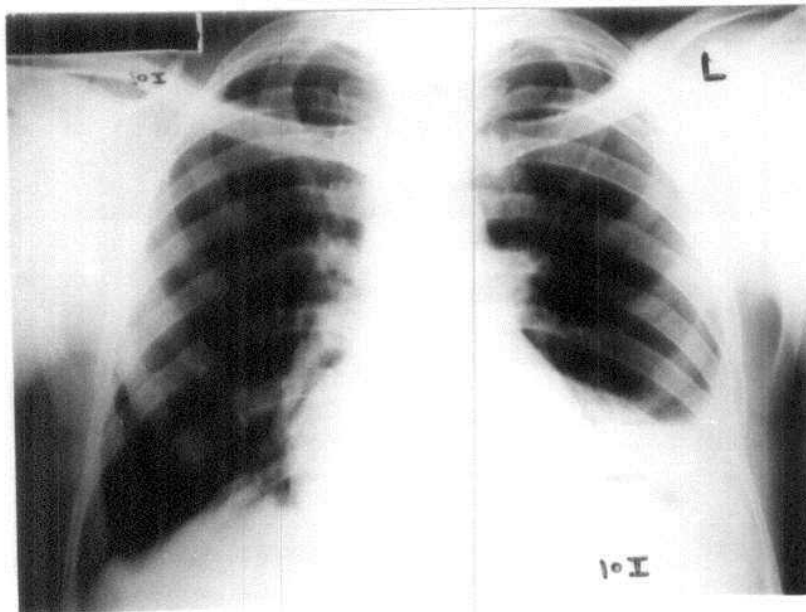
Postoperative chest radiograph for the same (four weeks after surgery): showing left basal lung opacity with left pleural effusion. The left coupla is high with sluggish movement by fluoroscopy. The picture suggested left subphrenic collection (confirmed by ultrasonography).
